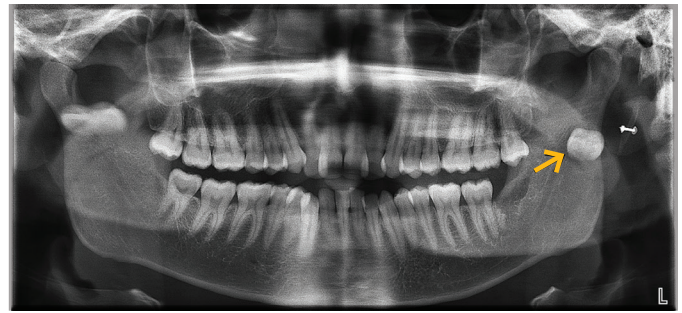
Panoramic radiograph showing the tooth fragment dislodged posterosuperiorly into the pterygomandibular space on the left side (arrow).
